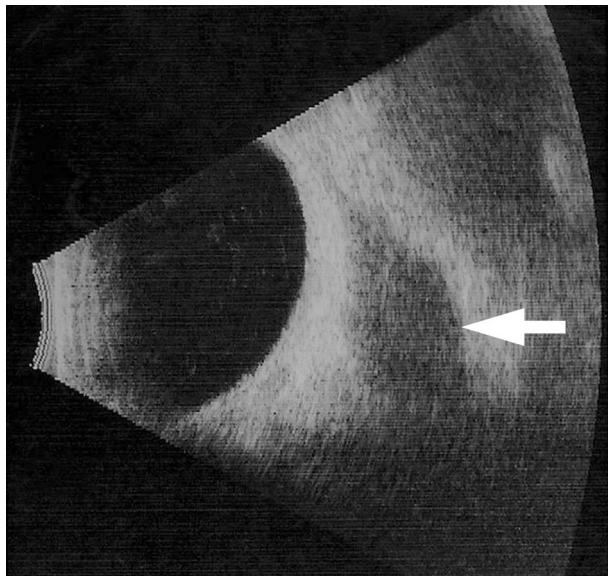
B-scan ultrasound showing a massively thickened inferior rectus muscle (arrow).
